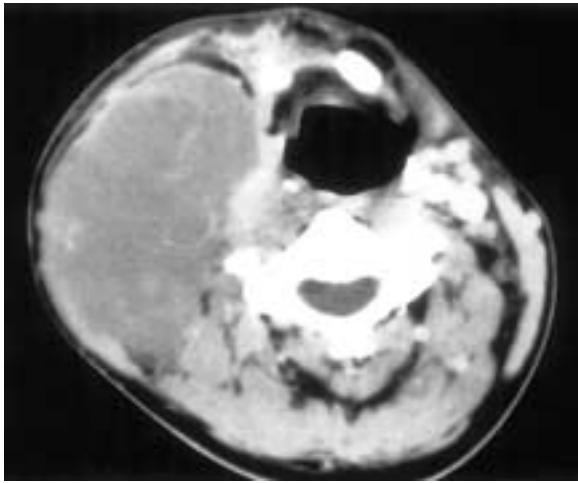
Axial contrast-enhanced CT scan shows a huge conglomerate nodal mass in the right level II region. The nodes are fairly homogeneous and have an attenuation less than that of muscle. This imaging appearance is highly suggestive of lymphoma. This patient had large cell lymphoma.
